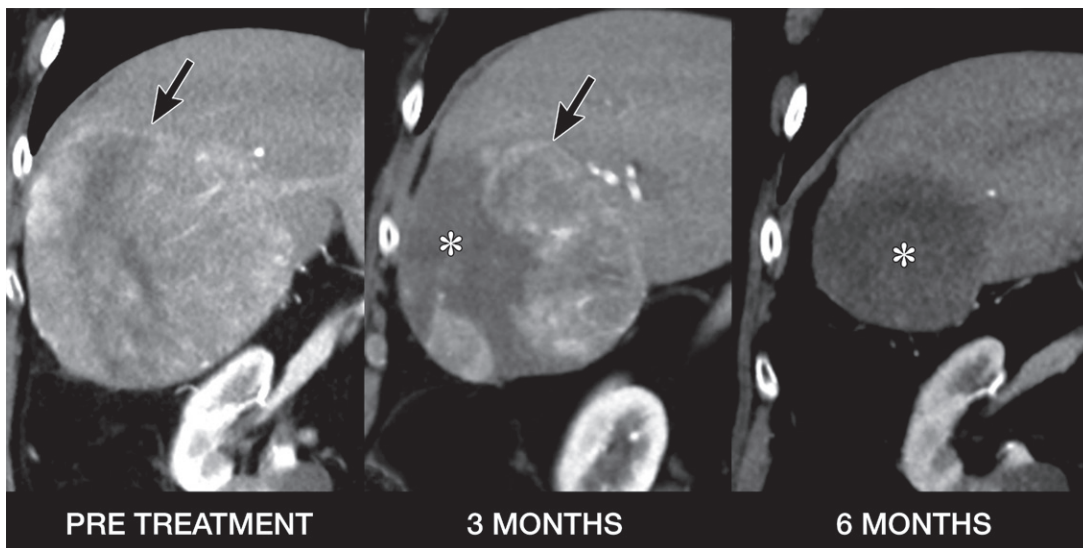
Coronal arterial phase CT images show tumor responses after TARE in an 80-year-old man. Left: Image obtained before TARE shows cirrhosis and HCC (arrow) in liver segments V–VIII. Middle: Image obtained 3 months after treatment shows a partial tumor response, with necrosis (*) and residual enhancement (arrow). Right: Image obtained 6 months after treatment shows complete necrosis (*).
